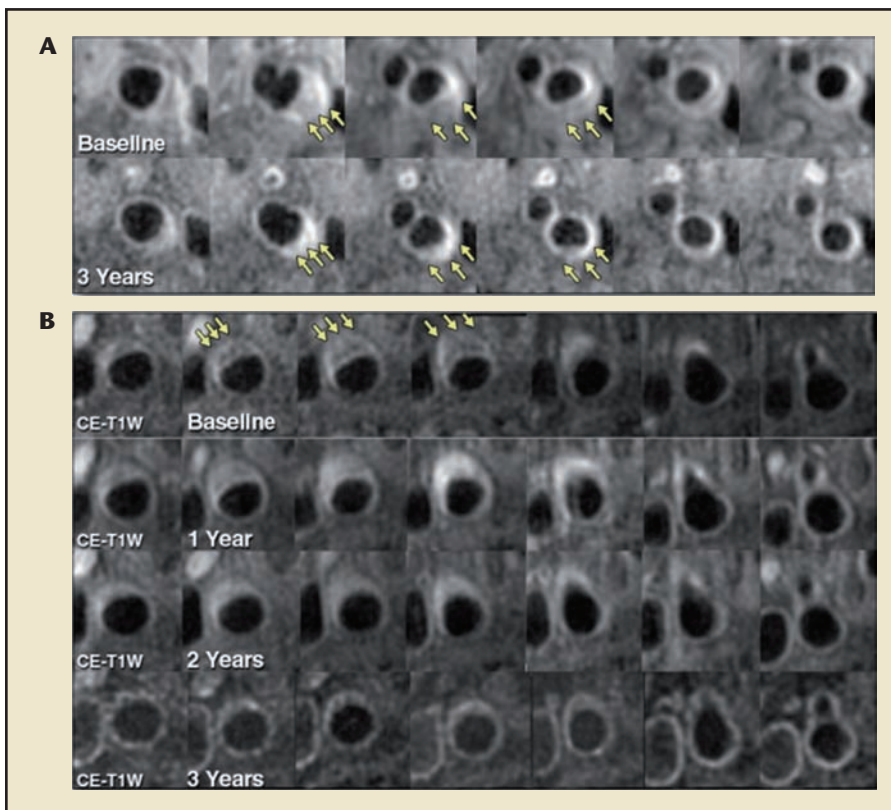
MRI examples of plaque lipid depletion and time course. (A) An example of significant lipid content reduction (yellow arrows) and plaque regression at 3 years compared with baseline in the left carotid artery. Overall, 11% of study subjects had completed plaque lipid depletion over 3 years. (B) MRI example of the plaque lipid depletion time course. Regression in LRNC size was notable between the baseline, 1-year, and 2-year MRI scans. Regression in plaque volume seemed to follow plaque lipid depletion and was most pronounced from years 1 to 3. CE, contrast enhanced; LRNC, lipid-rich necrotic core; MRI, magnetic resonance imaging; T1W, T1-weighted. Reprinted from Serruys PW et al. *J Am Coll Cardiol.* 2011;58:1578-1588; with permission from Cardiosource.
